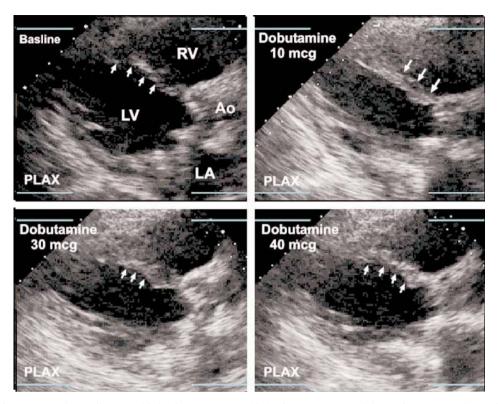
Dobutamine stress echocardiogram: biphasic response. A biphasic response on dobutamine stress echocardiography may be a candidate for coronary artery revascularization procedures. This patient shows augmentation of a previously poorly functioning region on low dose dobutamine (10 μ g), but demonstrates ischemia (decreased contractility) at higher doses. At baseline, this region of the heart (arrows) are hypokinetic—contractility improves at the 5 μ g infusion rate, is maintained at 10 μ g, worsens at 40 μ g. This represents an ischemic region that augmented at low doses that can benefit from revascularization. (Please *see* companion DVD for corresponding video.)
